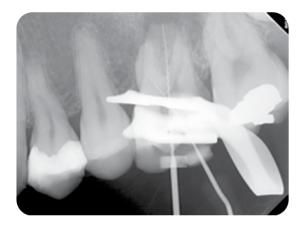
MB2 and P length-estimation radiograph (Day 1).
